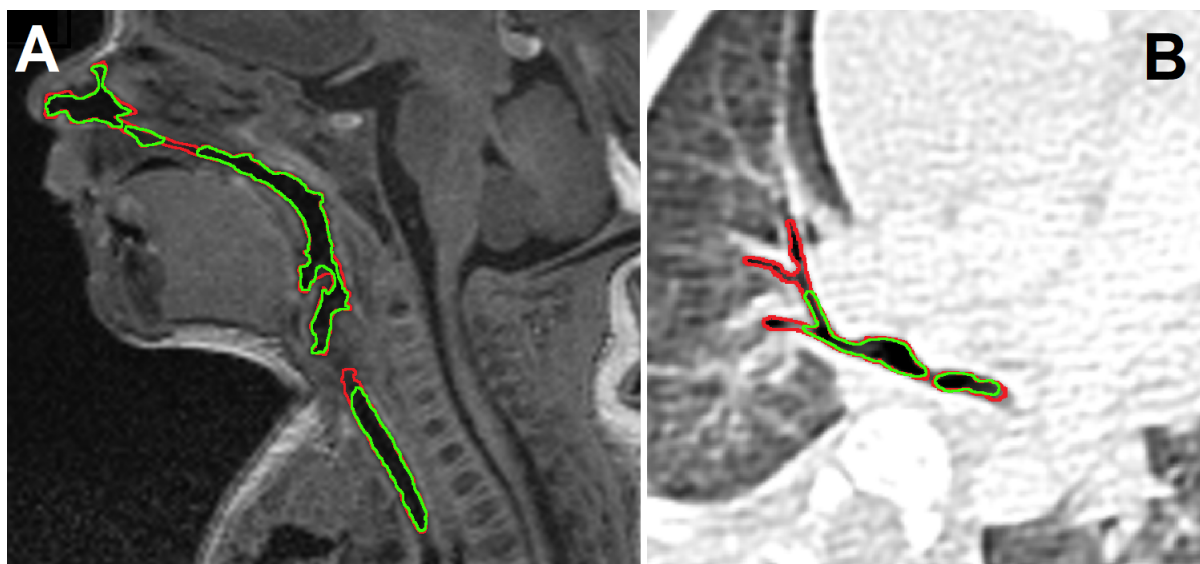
Segmented airways: Green line - automatic segmentation by Region Growing, Red line - fine manual adjustment. (A) MRI of head - sagittal view, (B) CT of lungs - transversal view
